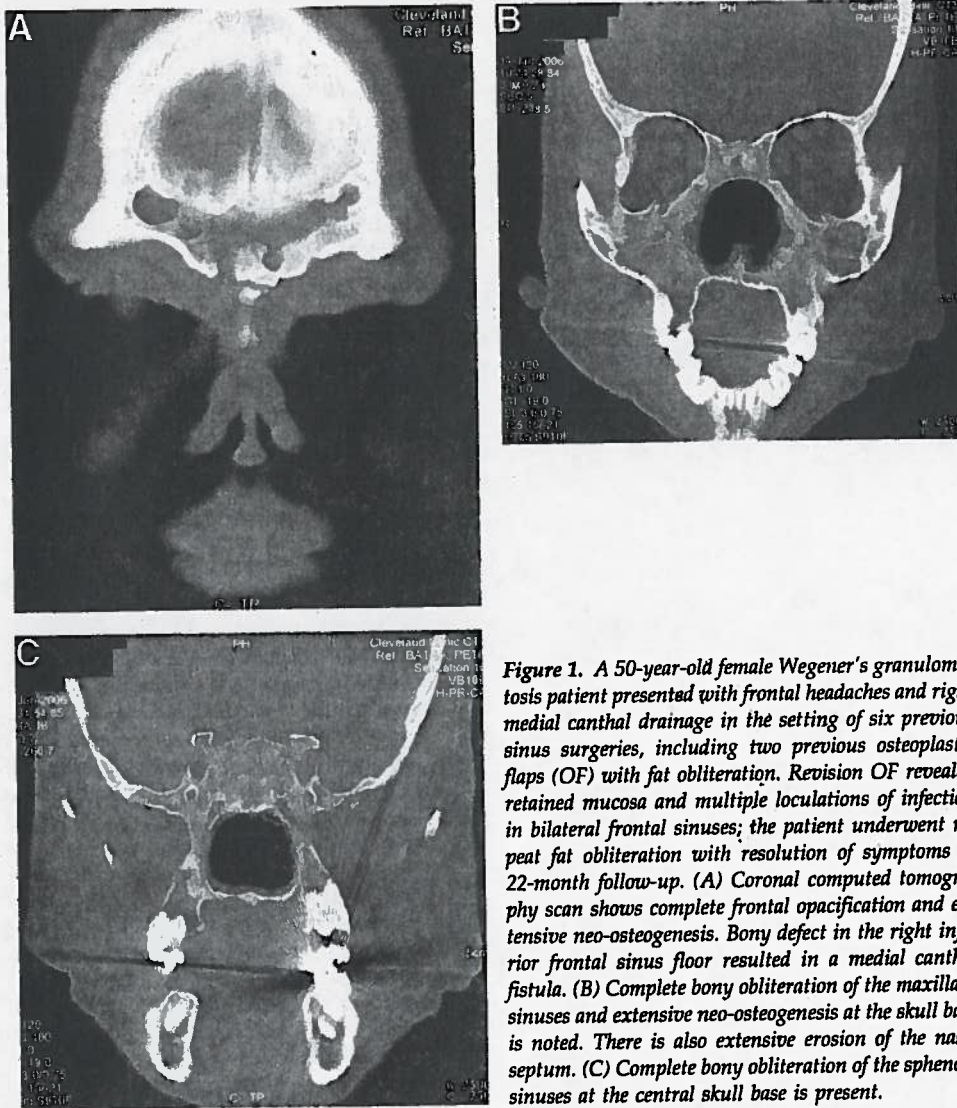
A 50-year-old female Wegener's granulomatosis patient presented with frontal headaches and right medial canthal drainage in the setting of six previous sinus surgeries, including two previous osteoplastic flaps (OF) with fat obliteration. Revision OF revealed retained mucosa and multiple loculations of infection in bilateral frontal sinuses; the patient underwent repeat fat obliteration with resolution of symptoms at 22-month follow-up. (A) Coronal computed tomography scan shows complete frontal opacification and extensive neo-osteogenesis. Bony defect in the right inferior frontal sinus floor resulted in a medial canthal fistula. (B) Complete bony obliteration of the maxillary sinuses and extensive neo-osteogenesis at the skull base is noted. There is also extensive erosion of the nasal septum. (C) Complete bony obliteration of the sphenoid sinuses at the central skull base is present.
